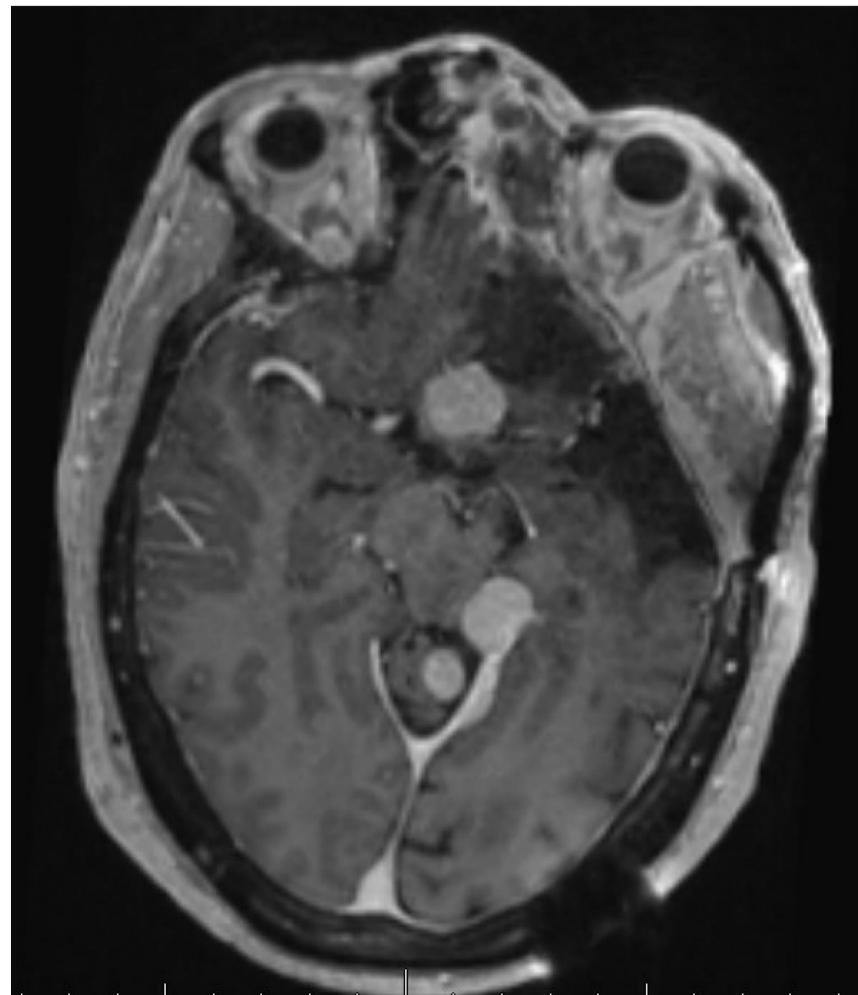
Preoperative imaging. Axial T1 MRI Brain post-contrast. Multifocal unilateral meningiomas.
